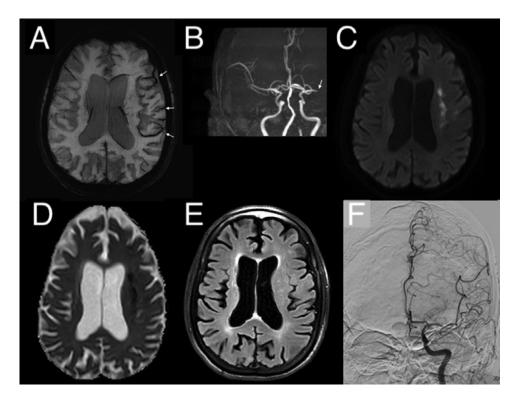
(A) Prominent hypointense vessels are noted at the region of the left middle cerebral artery (MCA) on the susceptibility-weighted imaging (SWI) sequence (white arrows). (B) MRA (magnetic resonance angiography) image showing cut-off of the M1 segment of the left MCA (white arrow). (C, D) Diffusion-weighted imaging (DWI) (C) and apparent diffusion coefficient (ADC) (D) images showing restricted diffusion representative of acute infarcts at the left MCA territory. (E) No corresponding hyperintensity is noted on the fluid attenuated inversion recovery (FLAIR) image (evidence of DWI-FLAIR mismatch). (F) Angiographic left ICA run showing recanalization of the truncated M1 segment of the left MCA, compared to the MRI done prior to the patient entering the angiography suite. Mechanical thrombectomy was not pursued in view of spontaneous complete recanalization observed (TICI 3).
